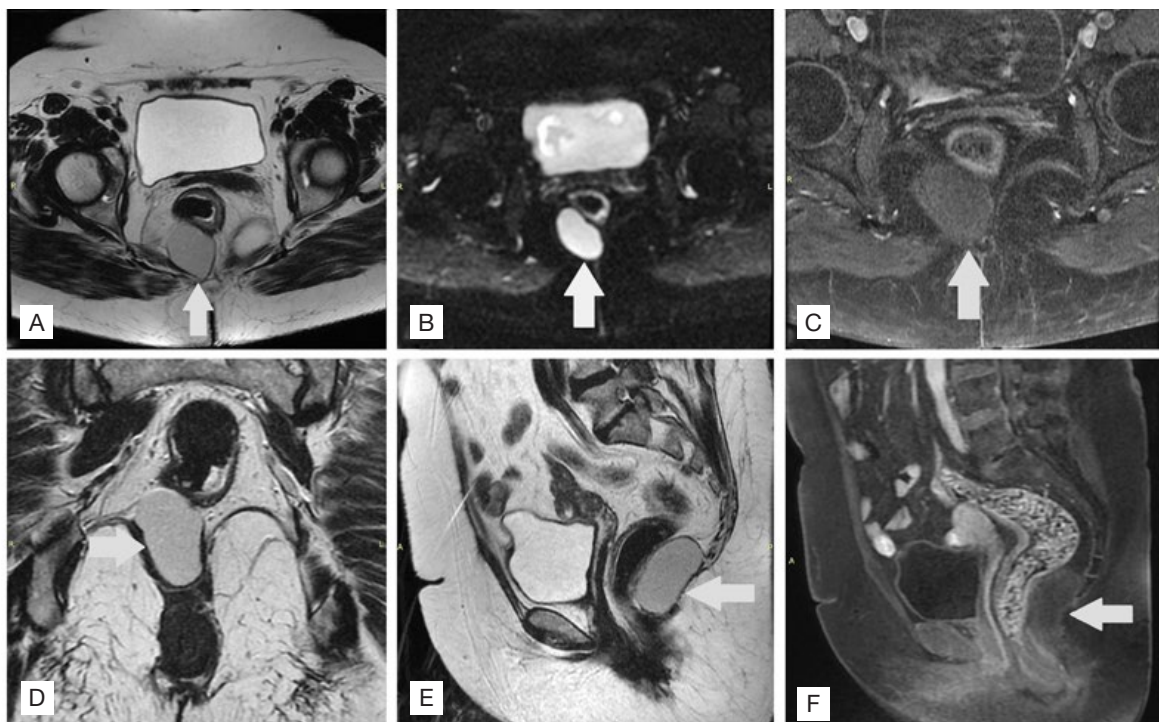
MRI in the axial section in the T2 (A), Diffusion (B), and T1 FAT SAT with contrast (C), in the coronal section in the T2 sequence (D) and the sagittal section in the T2 and LAVA sequences with contrast in E and F, respectively, demonstrating formation cystic-looking nodule in the posterior pararectal lower rectum region on the right, insinuating itself between the bundles of the puborectalis and levator ani muscles, partially adhered to the serosa of the rectum in its upper portion, with a plane of cleavage with the pre-vertebral region sacrococcygeal, without signs of pararectal fat infiltration, without significant contrast enhancement, compatible with retrorectal hamartoma – tailgut cyst.
